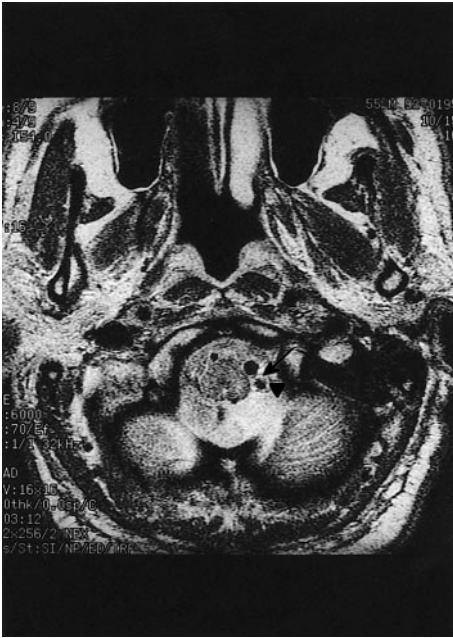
MRI of dissection of the lateral medullary segment of the PICA. The axial T1-weighted magnetic resonance image demonstrates thrombus within the false lumen of the dissected vessel as an area of increased signal (arrowhead) surrounding the true lumen, which was demonstrated as flow void (arrow)
